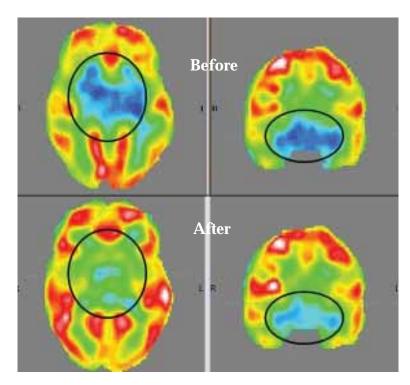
Pre and Post PET CT Scans showing improvements in Autism
